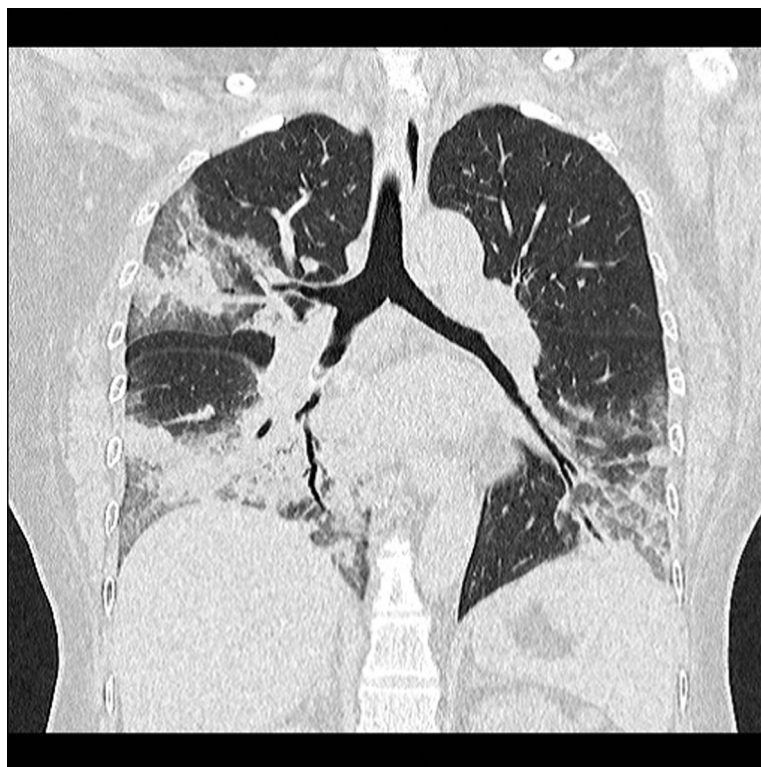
Coronal CT of the chest in pulmonary window 8 days after presentation showing multifocal patches of consolidation denser in lower lobes with air bronchogram.
